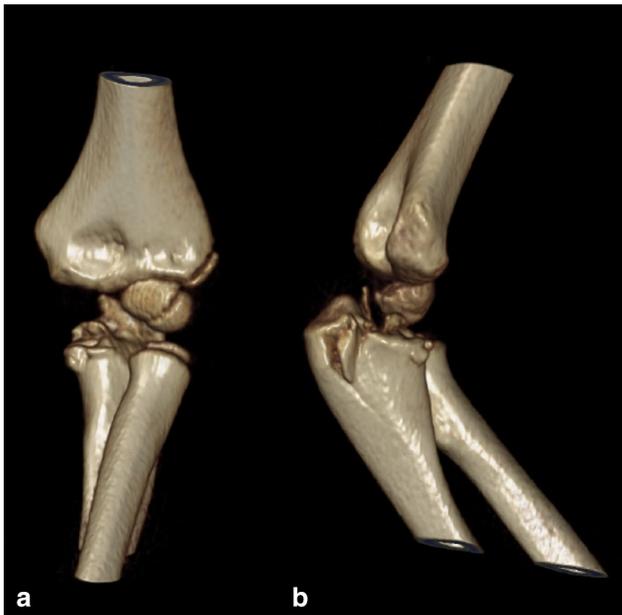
CT scan at the 4th post-traumatic day, 3D showing the fracture of the anteromedial facet and tip of the coronoid, detachment of the proximal medial cortex of the olecranon, intra-articular fragments
